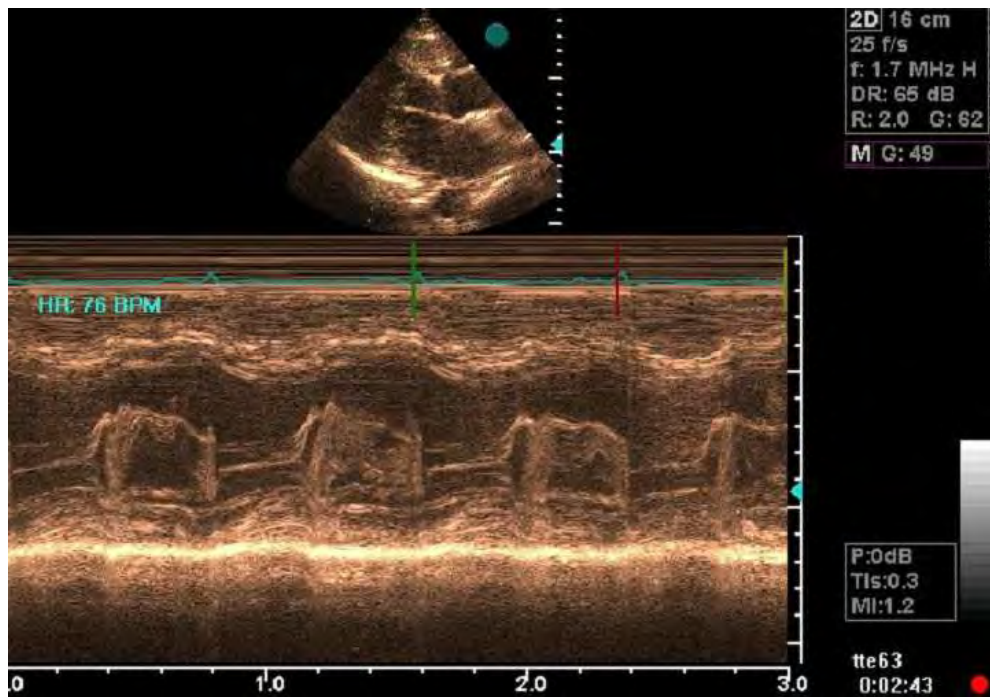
A 38 year old man with history of dyspnea. Myxoma can protrude through mitral valve and in M-mode mitral stenosis can be visualized as seen in this Echocardiograph.
